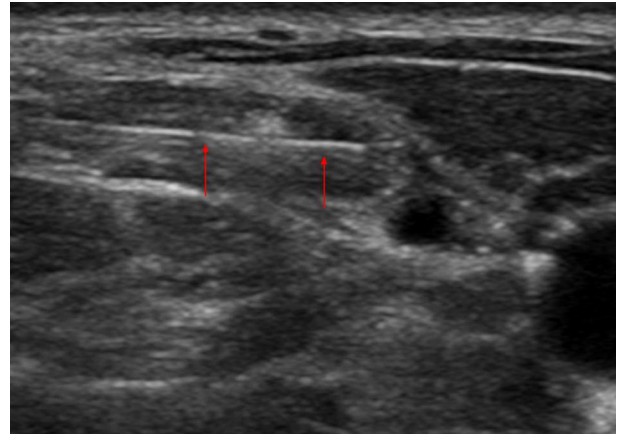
Ultrasound-guided superficial cervical plexus block at the left C4 level. An in-plane posterior-to-anterior approach is shown; the echogenic needle (red arrow) courses toward the fascial plane at the posterior border of the sternocleidomastoid muscle.
